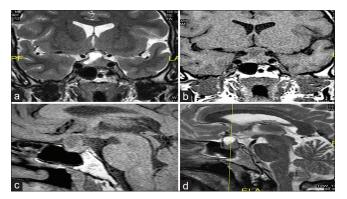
(a-d) MRI brain which showed an intrasellar, solid mass, with suprasellar cystic component
